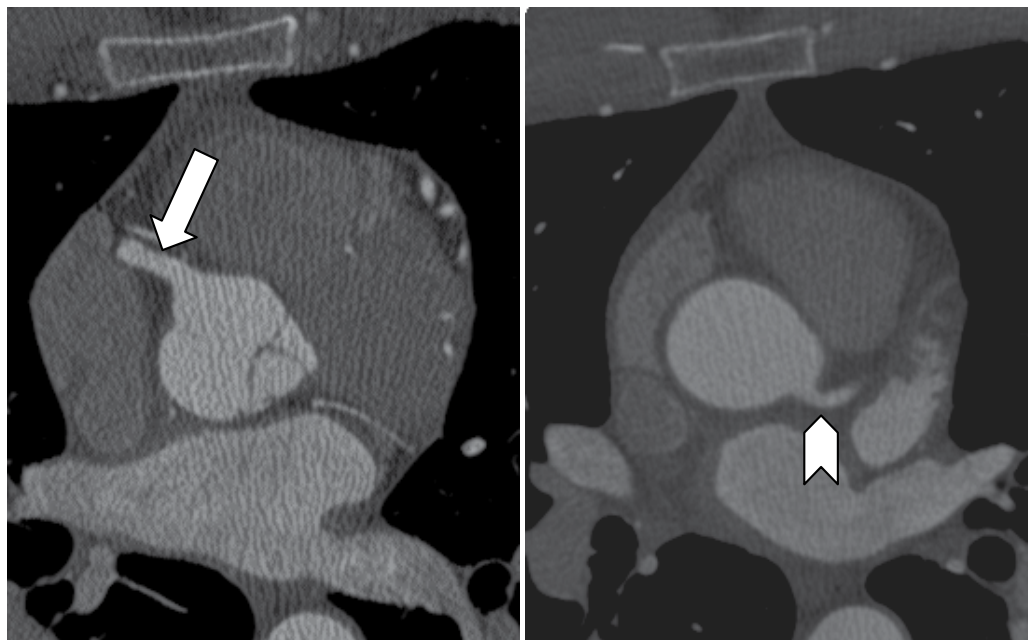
Axial cross-sectional computed tomography views showing normal origin of the right coronary artery (arrow) and left coronary artery (arrow head).
